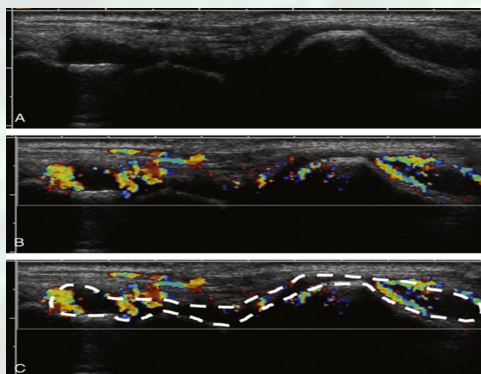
The hypertrophic synovium is identified (A), and the color Doppler image with maximum color activity is selected for analysis (B). The synovium inside the color box is traced, thereby outlining (dashed line) the region of interest (C). The amount of color pixels is expressed relative to the total amount of pixels in the marked region of interest; this is the color fraction.
